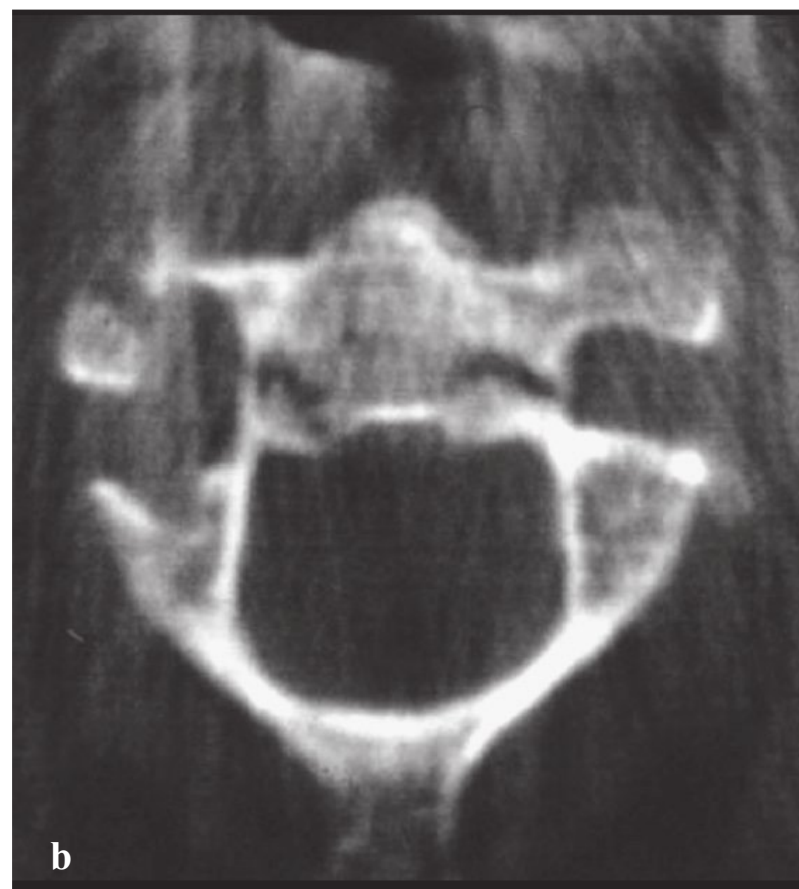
Lateral radiograph of a hangman's fracture (bilateral C2 pedicle fracture). (From Imhof H, ed. Spinal Imaging [Direct Diagnosis in Radiology]. Stuttgart, Germany: Georg Thieme Verlag; 2008: Fig. 2.18. Reproduced with permission.)
